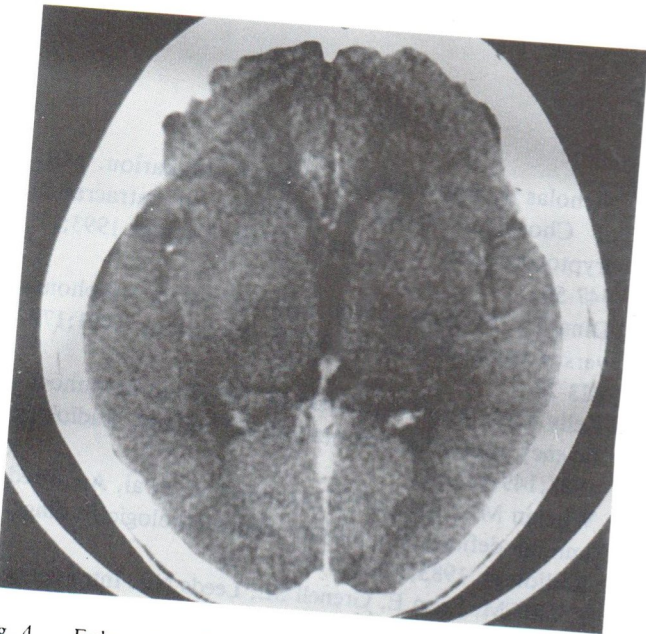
Enhanced CT scan showed enhanced small nodule without surrounding edema at right genu of Corpus Callosum, in cryptococcosis
